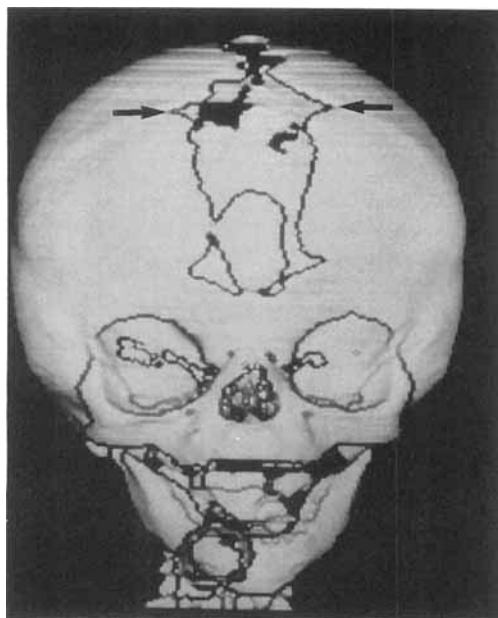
Three-dimensional reconstruction of CT scan showing bony island developing in midline calvarial defect. Note angular areas (arrows) representing patent coronal suture fissures superiorly.
